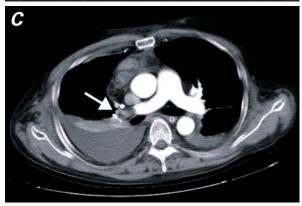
Transthoracic echocardiograms show A) right ventricular (RV) dilation compressing the left ventricle (LV) during cardio-pulmonary resuscitation (arrowheads) and B) attenuation of the RV dilation after 24 hours of heparin therapy. C) Chest computed tomogram shows a large embolus in the right main pulmonary artery (arrow), with a filling defect.
